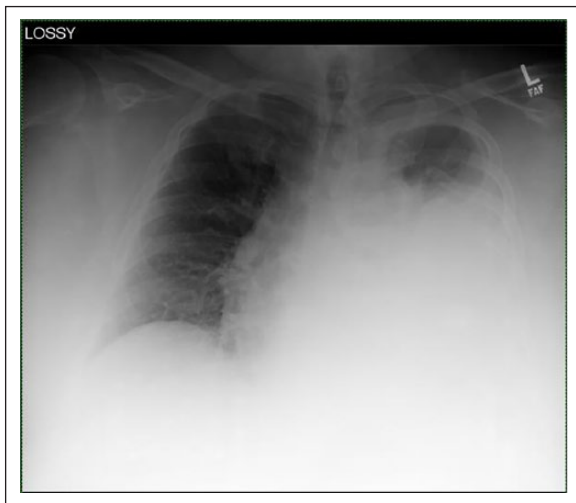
Anteroposterior chest radiograph on arrival to the emergency department shows a large opacity in left hemithorax.
